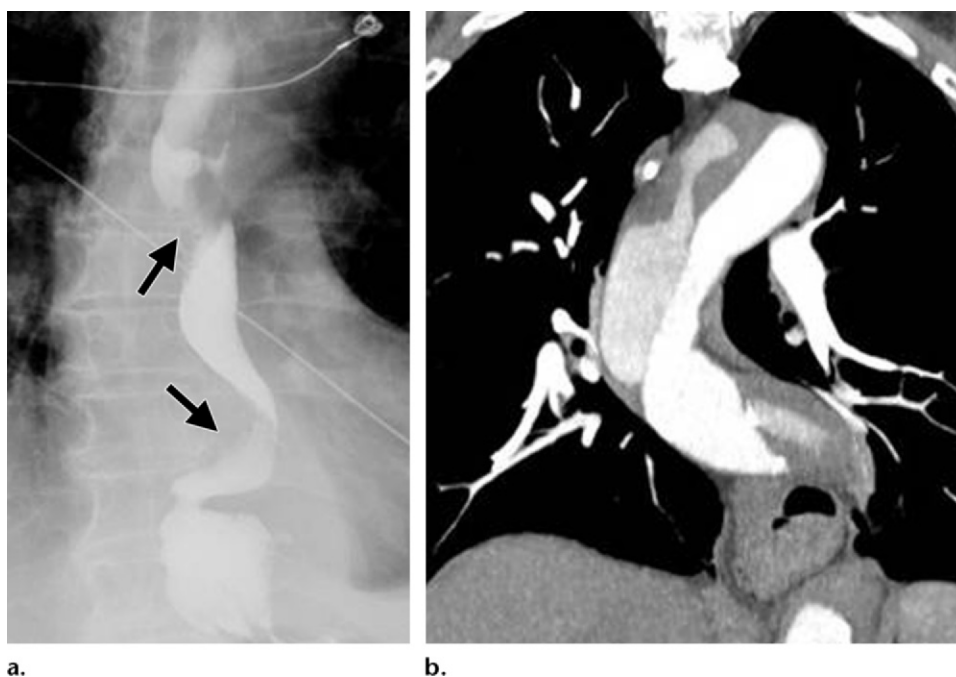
Dissecting thoracic aortic aneurysm. (a) Single-contrast anteroposterior image shows multifocal mass effect on the thoracic esophagus (arrows). (b) Coronal contrast-enhanced maximum-intensity-projection CT image reveals that the mass effect is due to a dilated thoracic aorta with aortic dissection.
